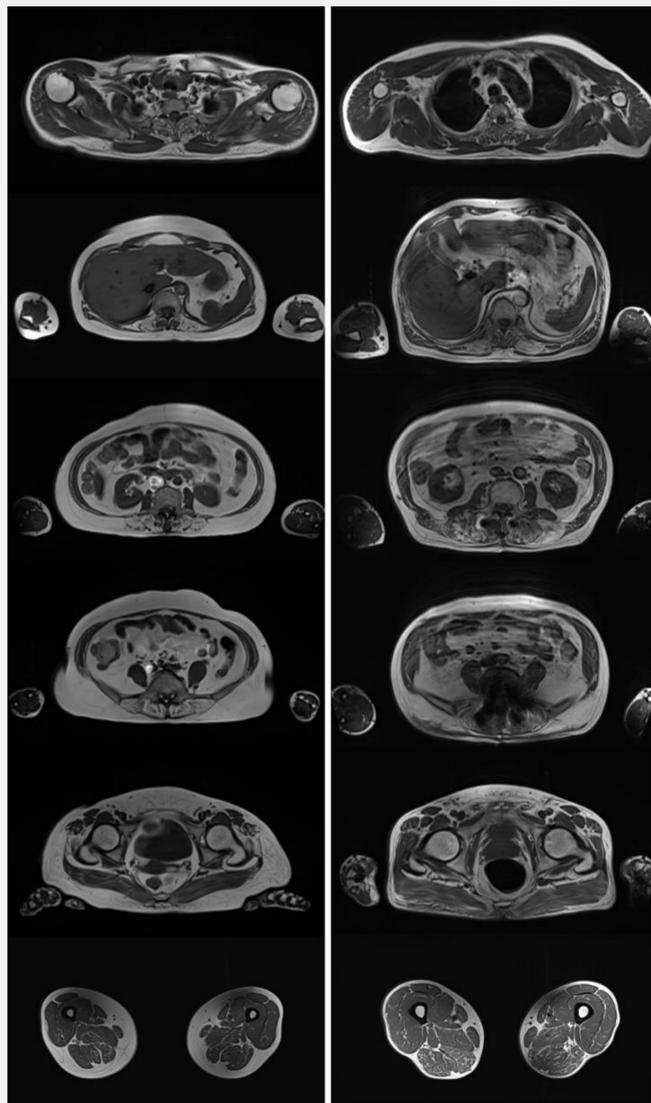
The T1 whole-body muscle MRI in the figure shows the T3, T10, L3, L5, femoral neck, mid-femur levels. Diffuse fatty atrophy was observed in the paravertebral muscles
